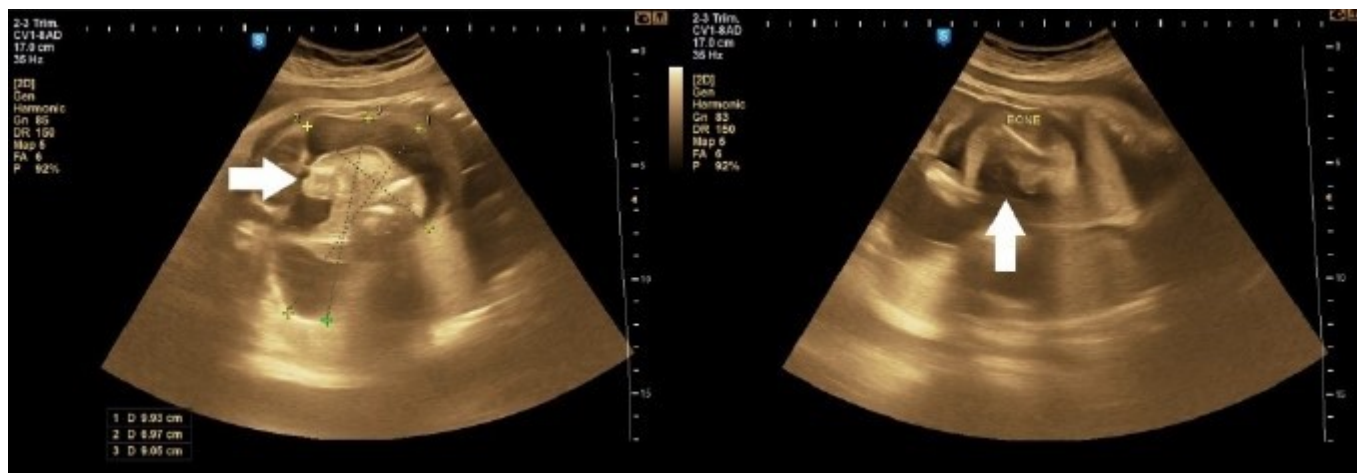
2D sonography images of fetal abdomen at 36 weeks gestation showing a fetal retroperitoneal abdominal complex mass showing heterogeneity with presence of cystic areas below the diaphragm and related to the right lobe of the liver.
